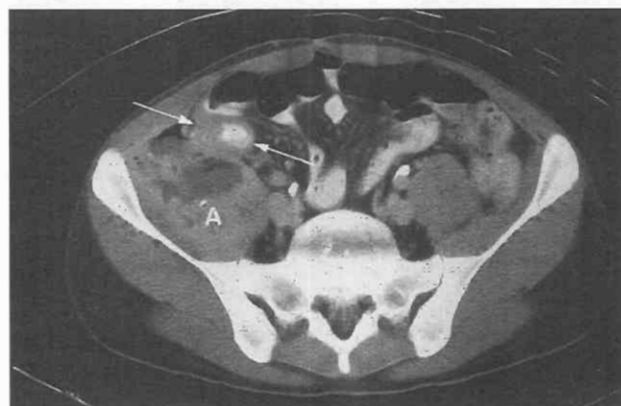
Abscess secondary to Crohn's disease. CT scan shows a right psoas muscle abscess (*A*) containing fluid and gas adjacent to a thick-walled small-bowel loop (arrows).
